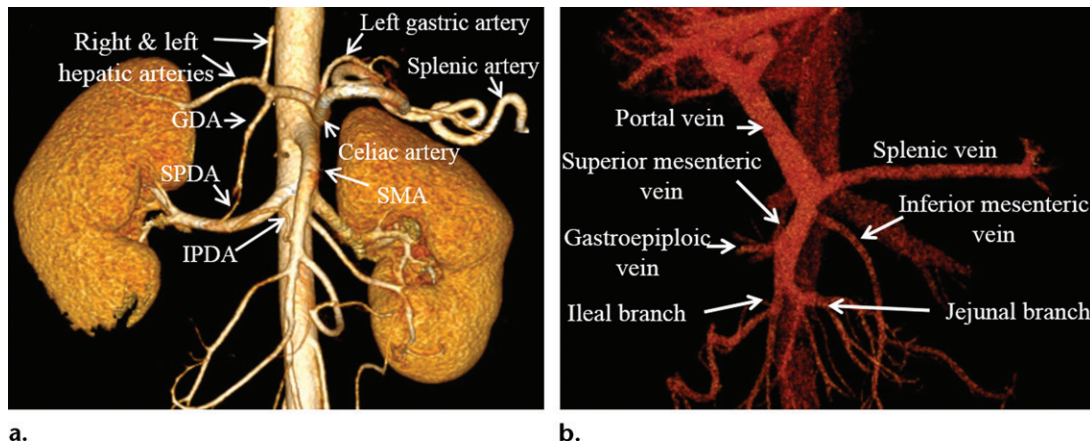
Peripancreatic vascular anatomic structures. Volume-rendered CT images show normal peripancreatic arterial (a) and venous (b) anatomic structures with images obtained in the arterial and venous phases, respectively. *GDA* = gastroduodenal artery, *IPDA* = inferior pancreaticoduodenal artery, *SPDA* = superior pancreaticoduodenal artery.
